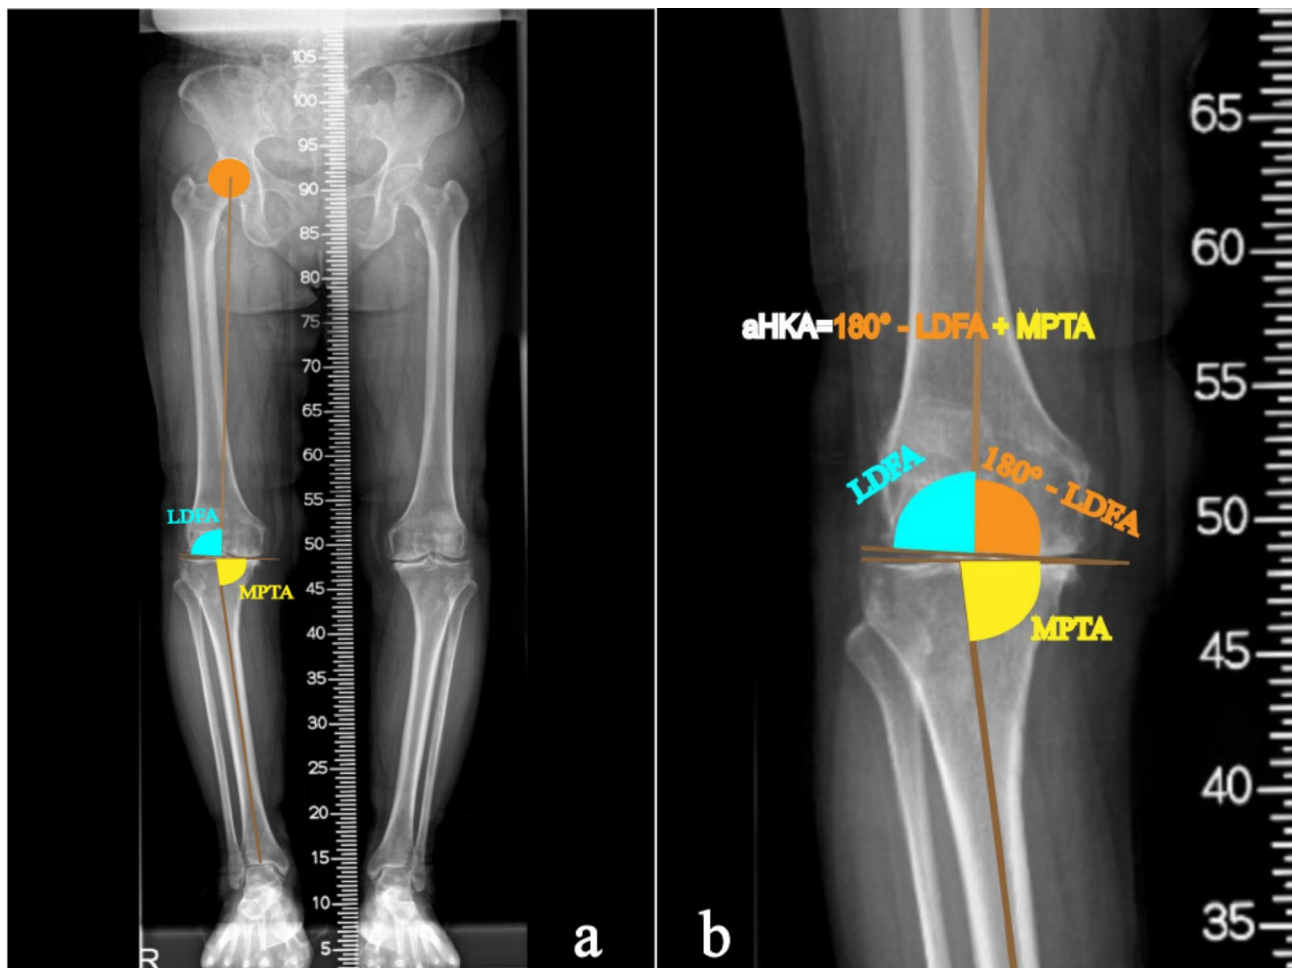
Measurement of the arithmetic hip-knee-ankle angle (aHKAA). (a) Preoperative weight-bearing long-leg radiograph showing the mechanical lateral distal femoral angle (LDFA) and the mechanical proximal tibial angle (MPTA). (b) Magnified view of the preoperative radiograph highlighting the measurement. The aHKAA was calculated using the formula $180^\circ + \text{MPTA} - \text{LDFA}$
